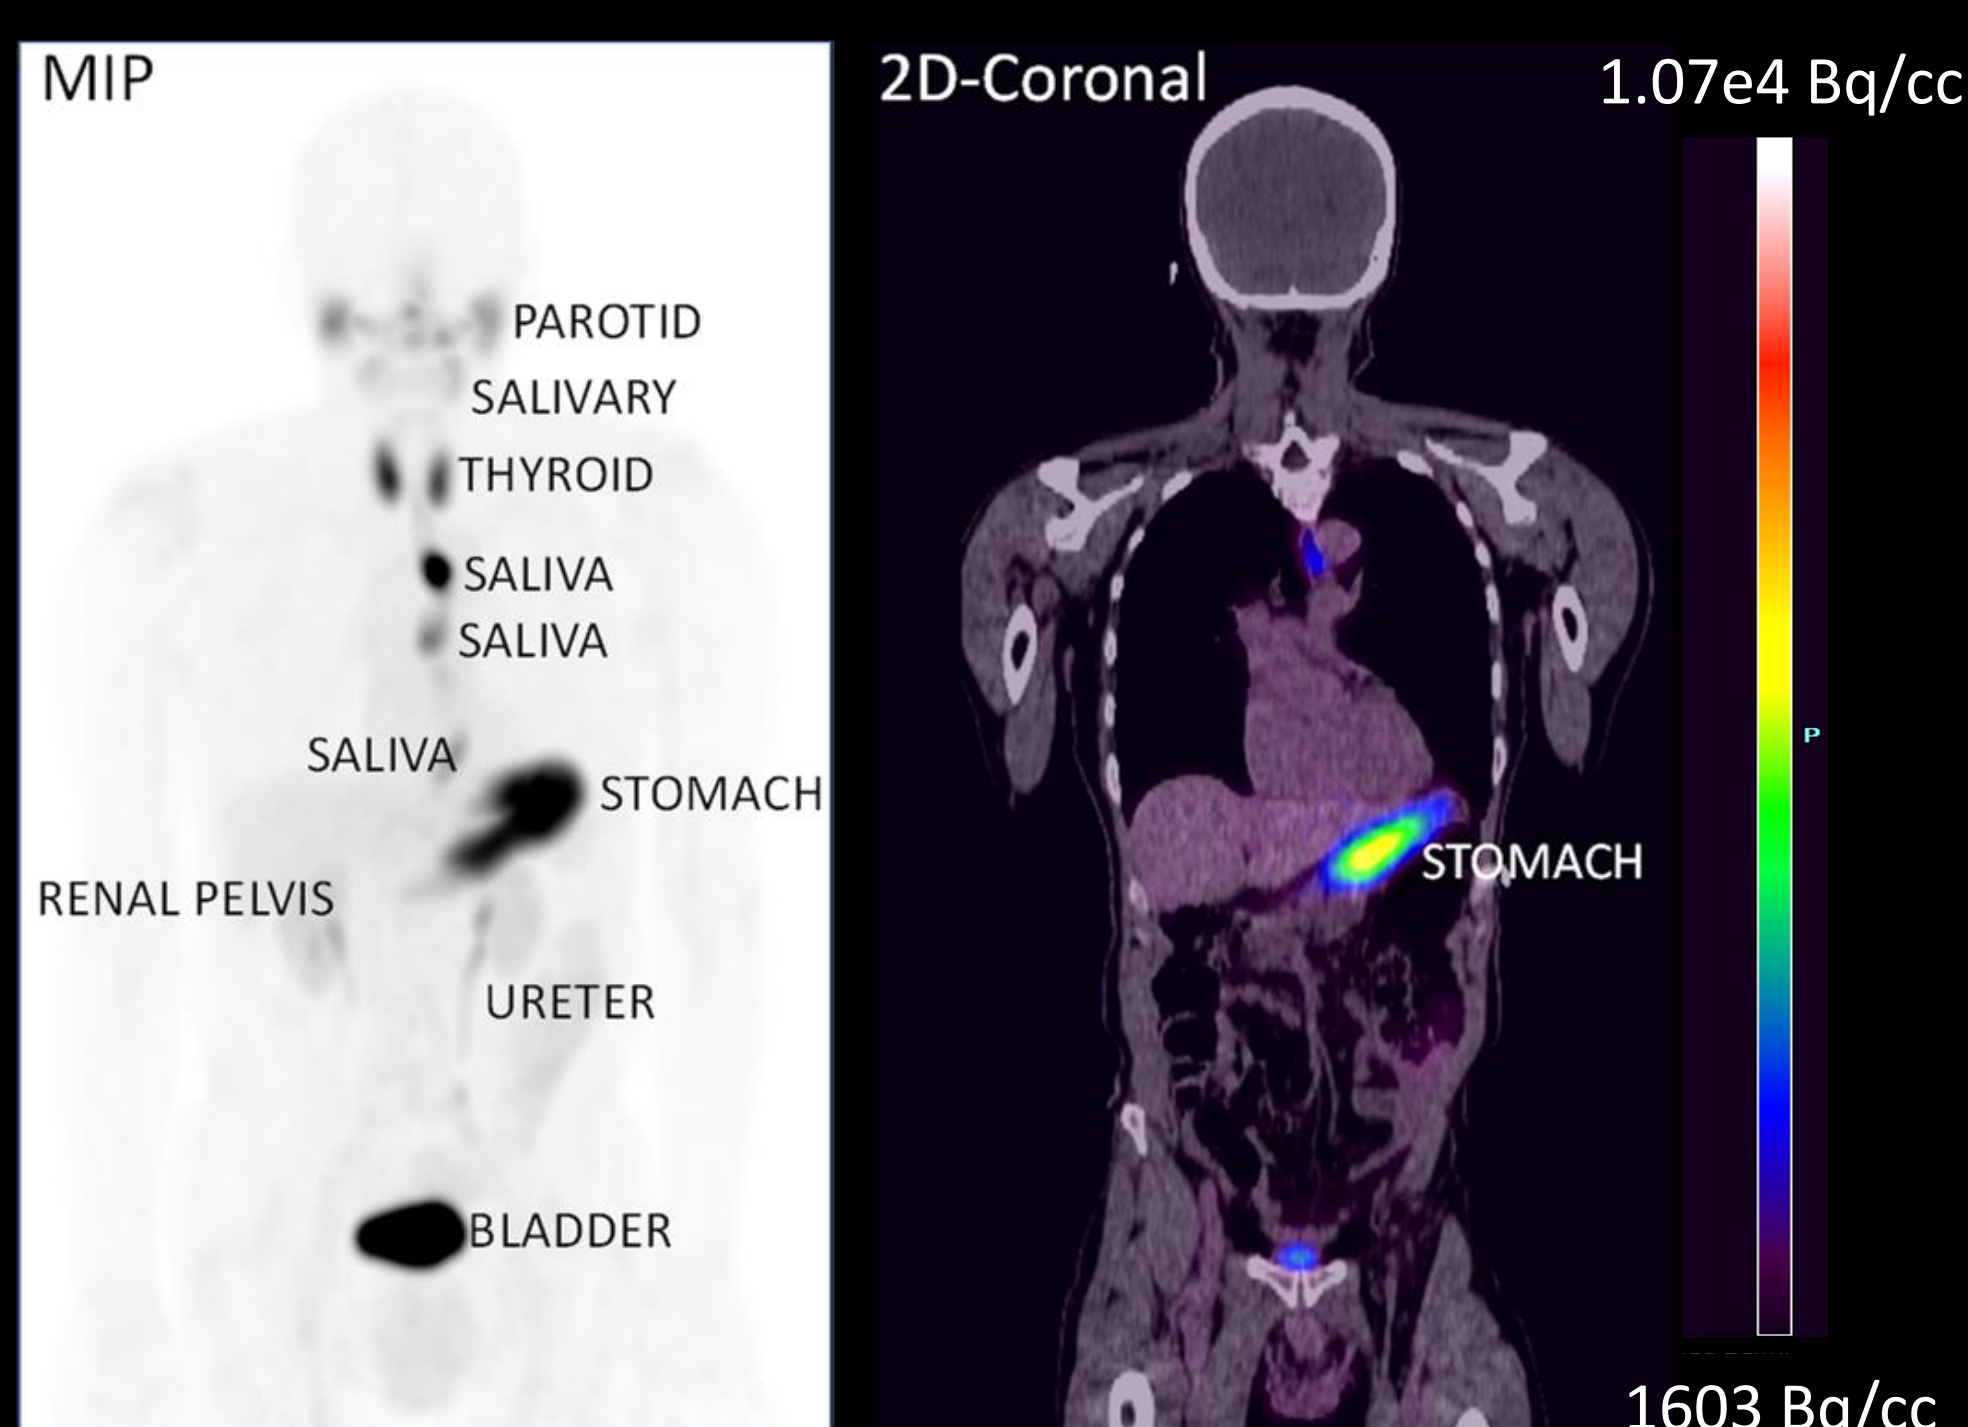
Representative images of ^{124}I -AT-01 in a healthy individual. Maximum intensity projection (left) and 2D coronal PET/CT (right) images reveal physiological distribution of free iodide following dehalogenation of the radiotracer (during renal catabolism), in the parotid, salivary and thyroid glands, the stomach lumen, and areas of renal excretion, including the renal pelvis, ureter and bladder.
